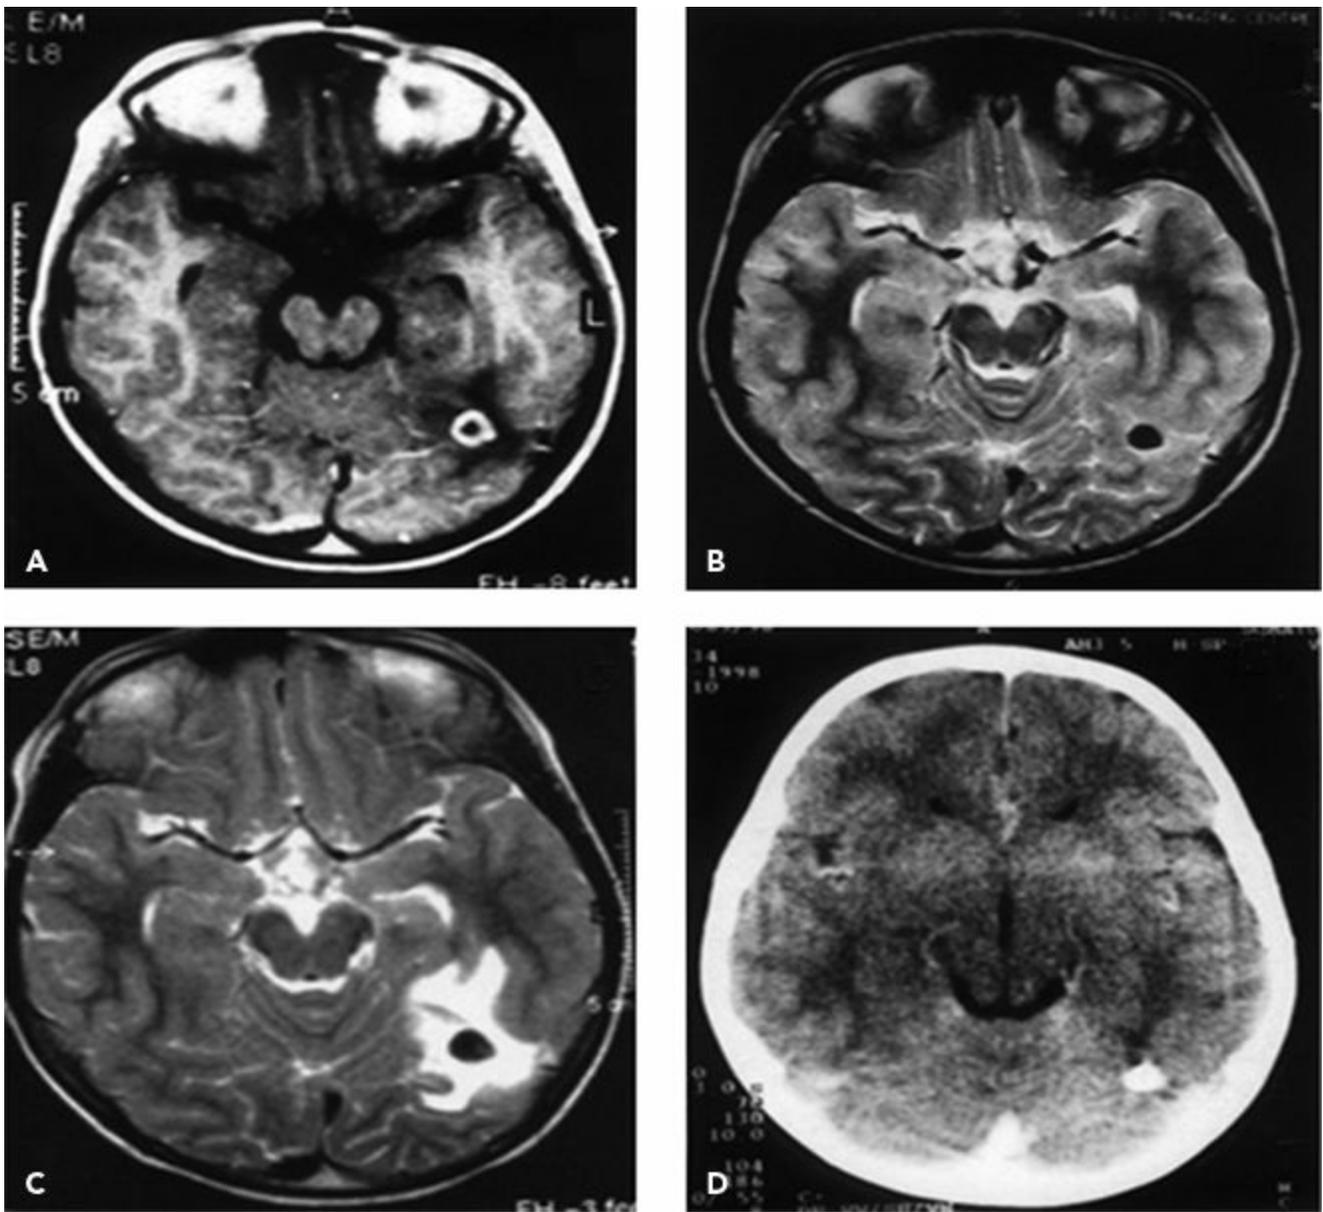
Resolution of a cysticercus granuloma and the subsequent reappearance and resolution of perilesional edema. A: Initial gadolinium-enhanced MRI in a patient with recent seizures showing a single annular-enhancing lesion. B: Follow-up T2-MRI 6 months later showing resolution with calcification. C: T2-MRI performed another 14 months later, when the patient developed seizure recurrence, showing perilesional edema around the calcific nodule. D: CT scan performed another 6 months later showing resolution of the edema around the calcific nodule. (From Singh G, Prabhakar S. *Taenia solium* Cysticercosis: From Basic to Clinical Science. Oxon, UK: CAB International, with permission.)
